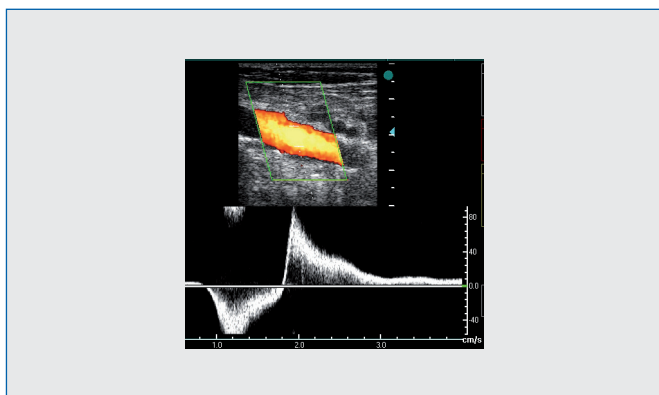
Identification with color duplex ultrasound and pulsed duplex ultrasound of a reflux greater than 1 second in a popliteal vein.
